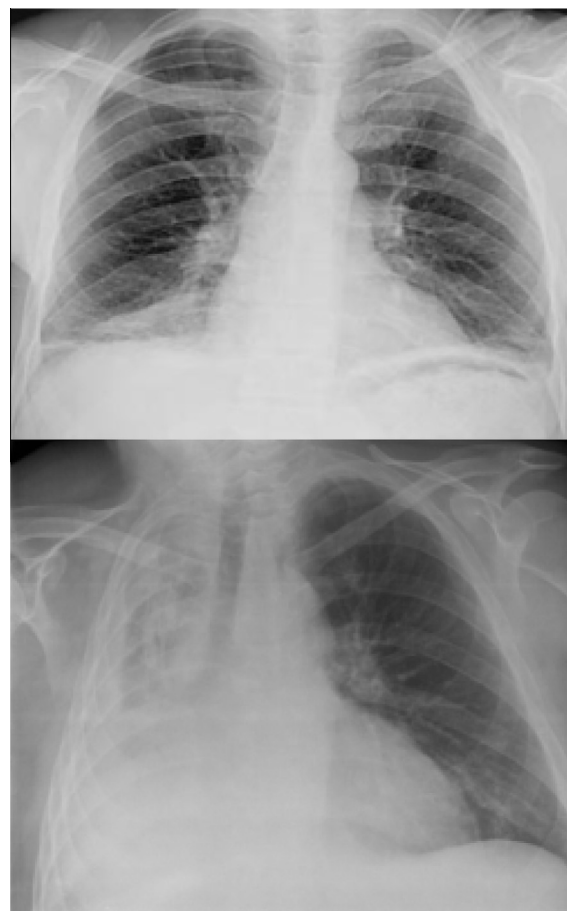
Chest X-ray before and after cryotherapy with Rt. lung collapse resolution.
